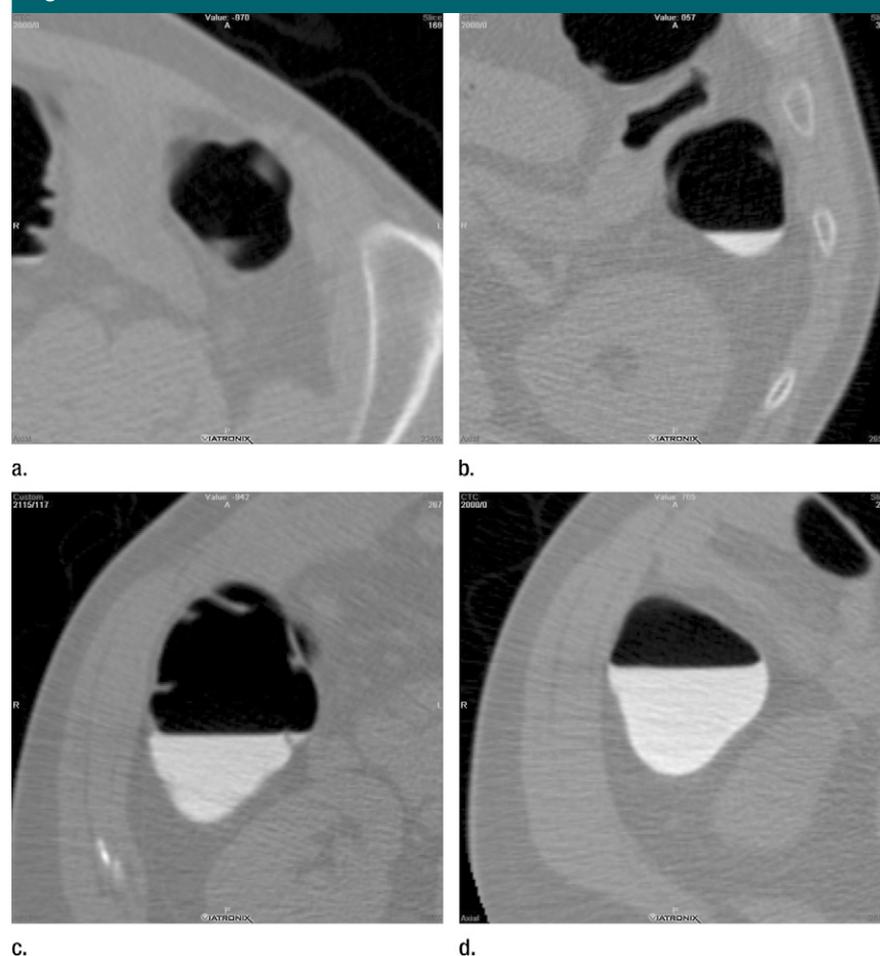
Axial two-dimensional CT colonographic images show stool scoring system. (a) Fluid score of 1: no residual fluid. (b) Fluid score of 2: less than 25% of the lumen filled with fluid. (c) Fluid score of 3: 25%–50% of the lumen filled with fluid. (d) Fluid score of 4: more than 50% of the lumen filled with fluid.
